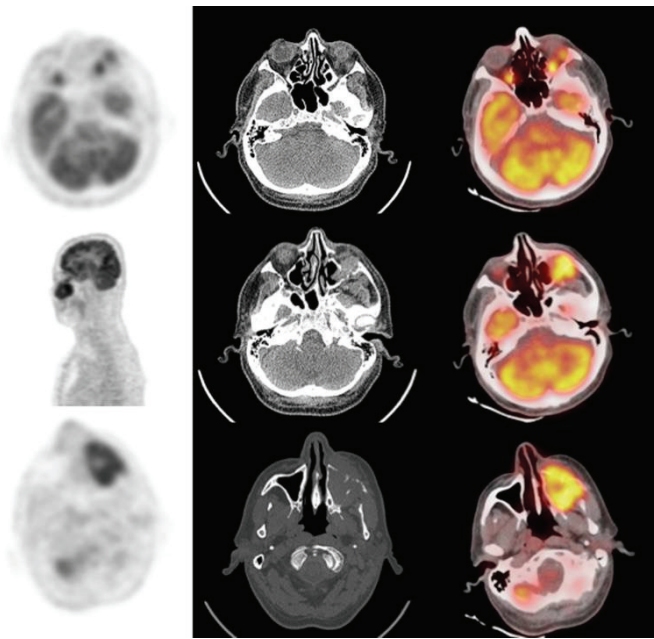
PET/CT images demonstrated a destructive lesion with high FDG uptake inside the maxillary sinus and extending to the soft tissue surrounding left orbita
